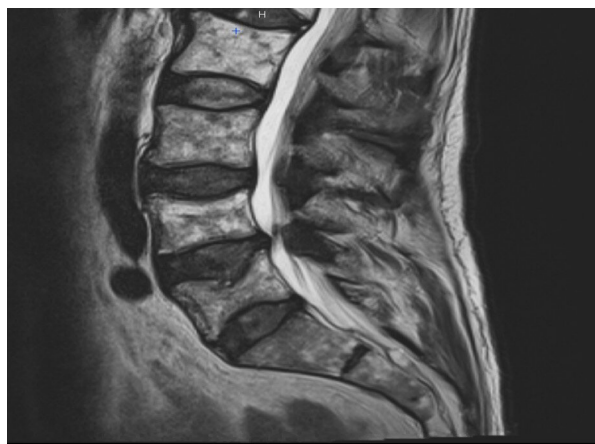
Spinal MRI shows severe L3–L4 and L4–L5 spinal stenosis and foraminal stenosis.
